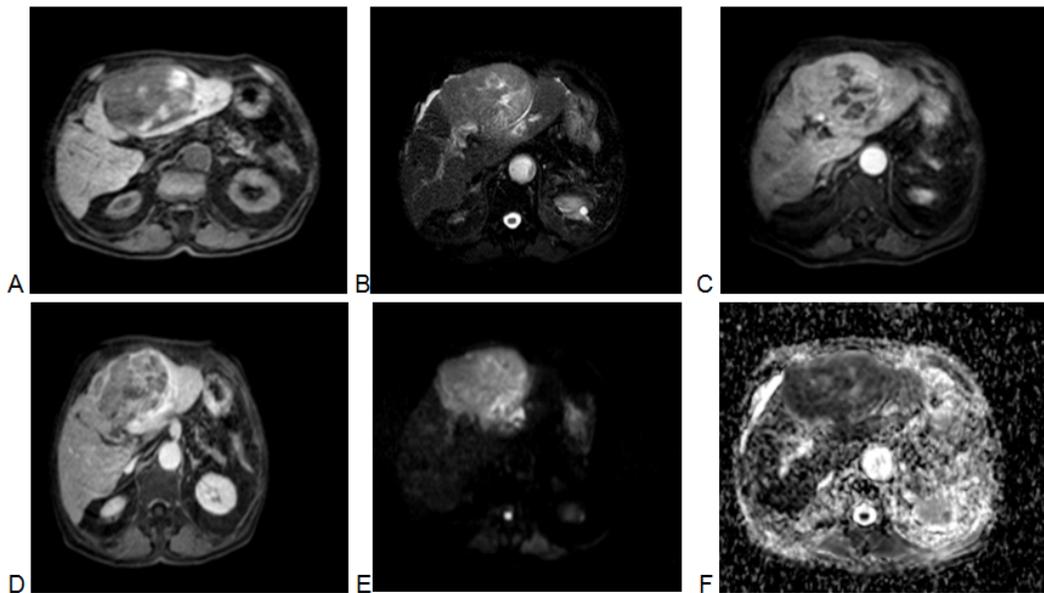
Residual active viable tumoral tissue following TACE. (A, B) axial T1 & T2 SPAIR WIs obtained 1 month after TACE. The embolized zone in the left hepatic lobe elicits low T1 and elevated T2 SPAIR signal (C). axial arterial phase image, (D) axial equilibrium phase image, the ablation zone shows gross heterogeneous pathological lesional contrast enhancement with rapid washout denoting active viable tumoral tissue. (E, F) Diffuse lesional hyperintensity is noted on DWI with corresponding low signal noted on ADC map denoting diffusion restriction.
